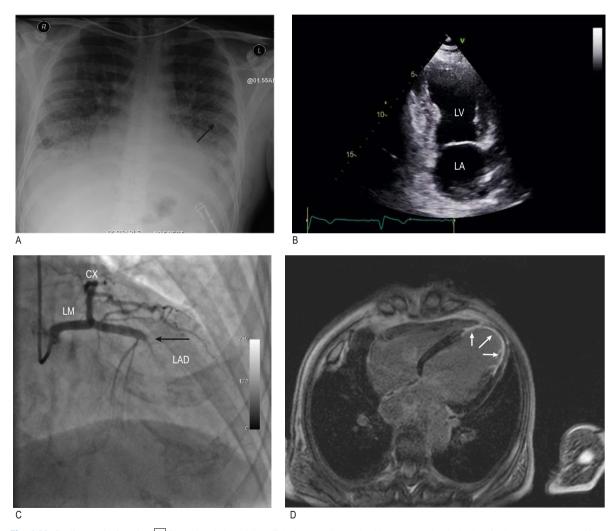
Cardiovascular imaging. A Chest X-ray in heart failure. This shows cardiomegaly with patchy alveolar shadowing of pulmonary oedema and Kerley B lines (engorged lymphatics, *arrow*) at the periphery of both lungs. B Transthoracic echocardiogram in an apical two-chamber view, showing thinning of the left ventricular apex. This is the site of a recent anterior myocardial infarct. *LA*, Left atrium; *LV*, left ventricle. C Coronary angiography. The *arrow* indicates an abrupt occlusion of the proximal left anterior descending artery. *CX*, circumflex; *LAD*, left anterior descending; *LM*, left main. D Cardiac magnetic resonance imaging. Gadolinium enhancement image demonstrates regional uptake of gadolinium (*white arrows*) consistent with myocardial fibrosis in the territory of the LAD.
